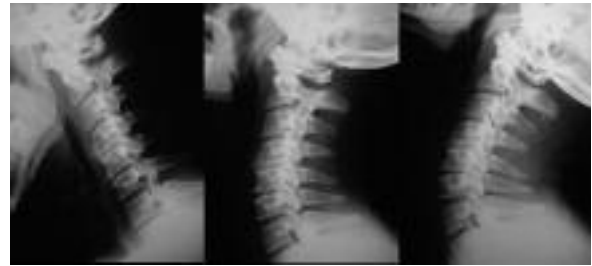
Preoperative (2005) cervical x-rays with flexion (*left*), neutral (*middle*) and extension (*right*) views showing a reduced disc height at C4/C5, along with a kyphotic angulation, with increased interspinous process distance, and absence of angular movement at the same level.
